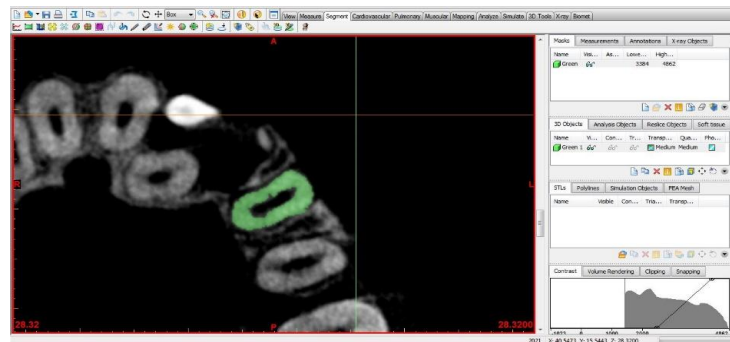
Graphic view of CT file
